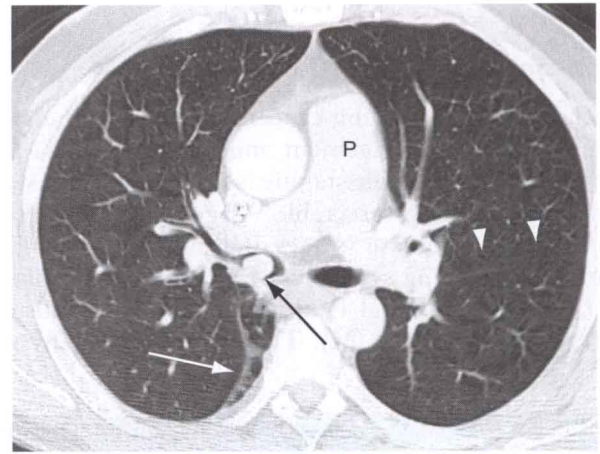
The patient was a 47-year-old man who presented with a new cough. Contrast-enhanced chest CT scan shows a nodule (black arrow) within the bronchus intermedius, causing some atelectasis of the right lower lobe, as depicted by the displacement of the right major fissure (white arrow). Compare the normal position of the left major fissure (white arrowheads). Nodule was removed endobronchially and proved to represent carcinoid. P, main pulmonary artery.
